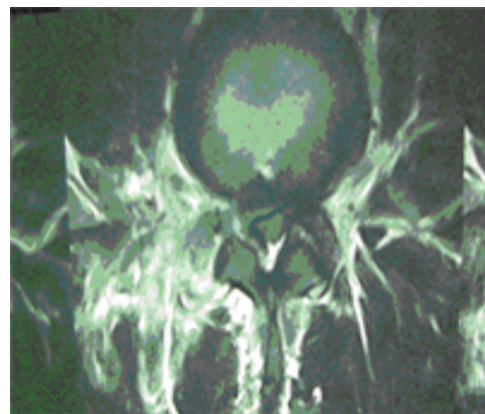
MRI(axial view) from L4-L5 inter vertebral disc .
